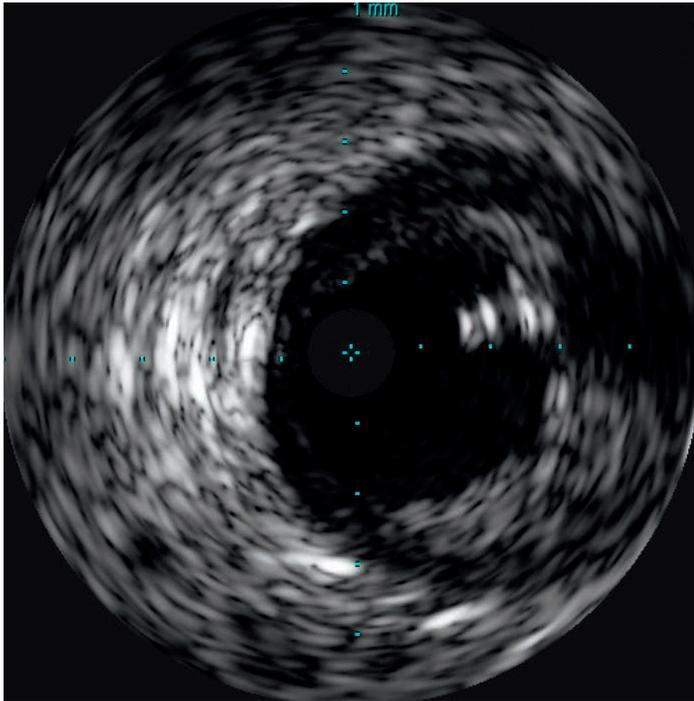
Intravascular ultrasound demonstrating retained wire (2 to 3 o'clock position).
